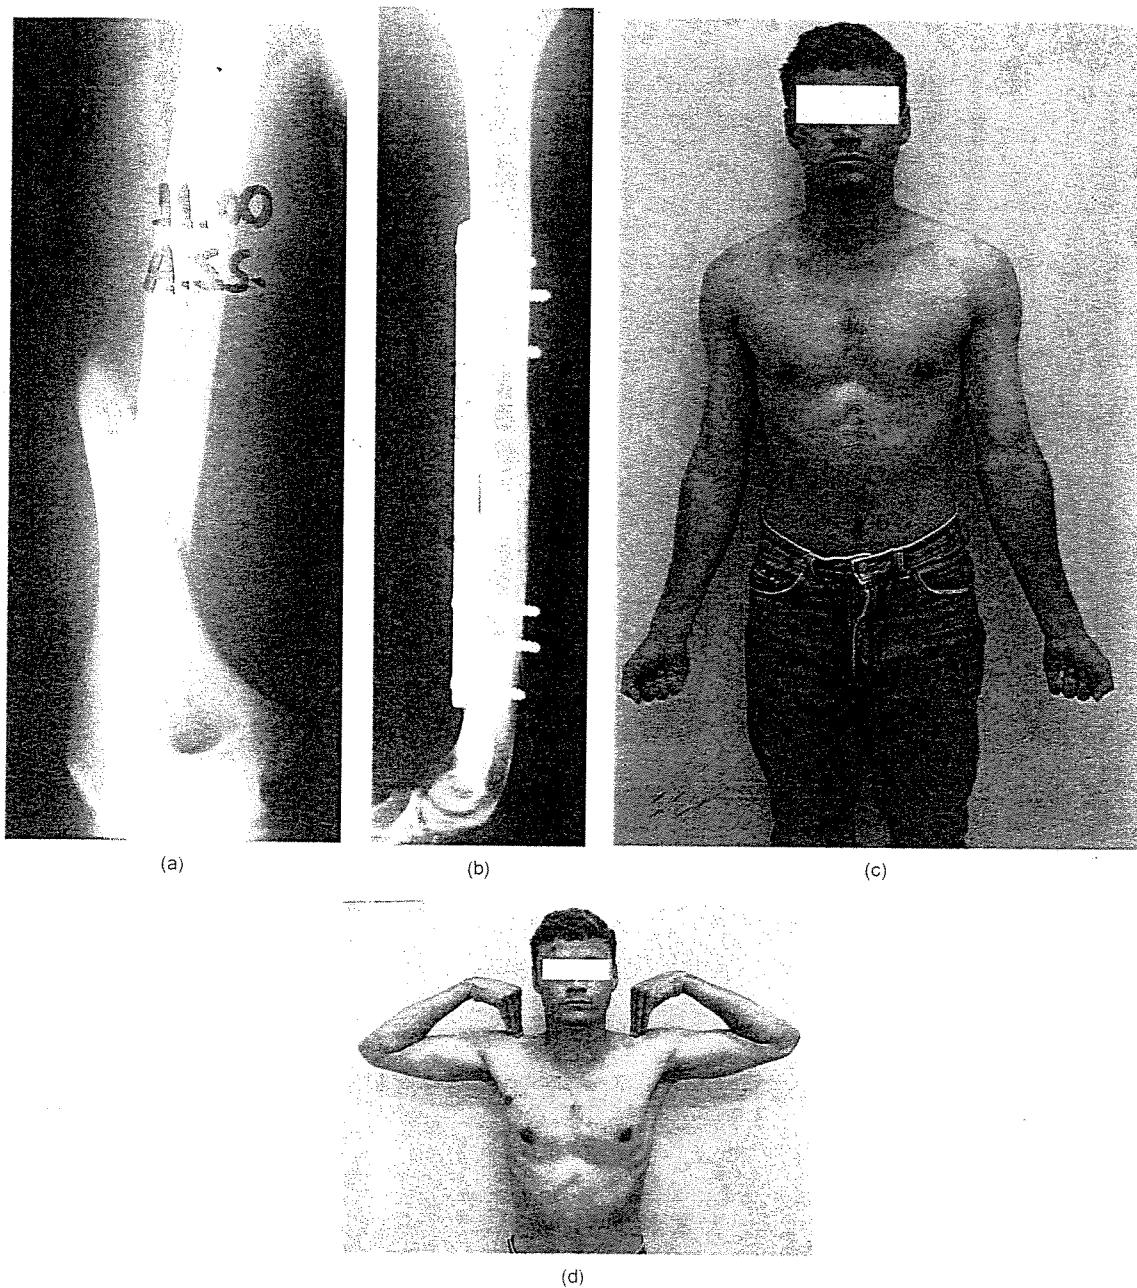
(a) Case number 5: preoperative X-ray; (b) case number 5: 1 year postoperative X-ray; (c) case number 5: final elbow carrying angle; and (d) case number 5: shoulder and elbow arch of movement.
